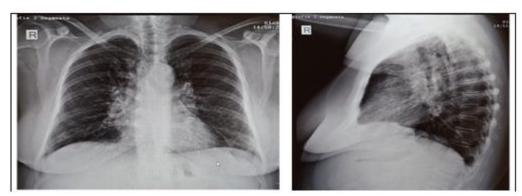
Chest X-ray: reticular changes in the basal segments of the lower lobes, enlarged bilateral hilum, absence of focal opacity, normal size cord
